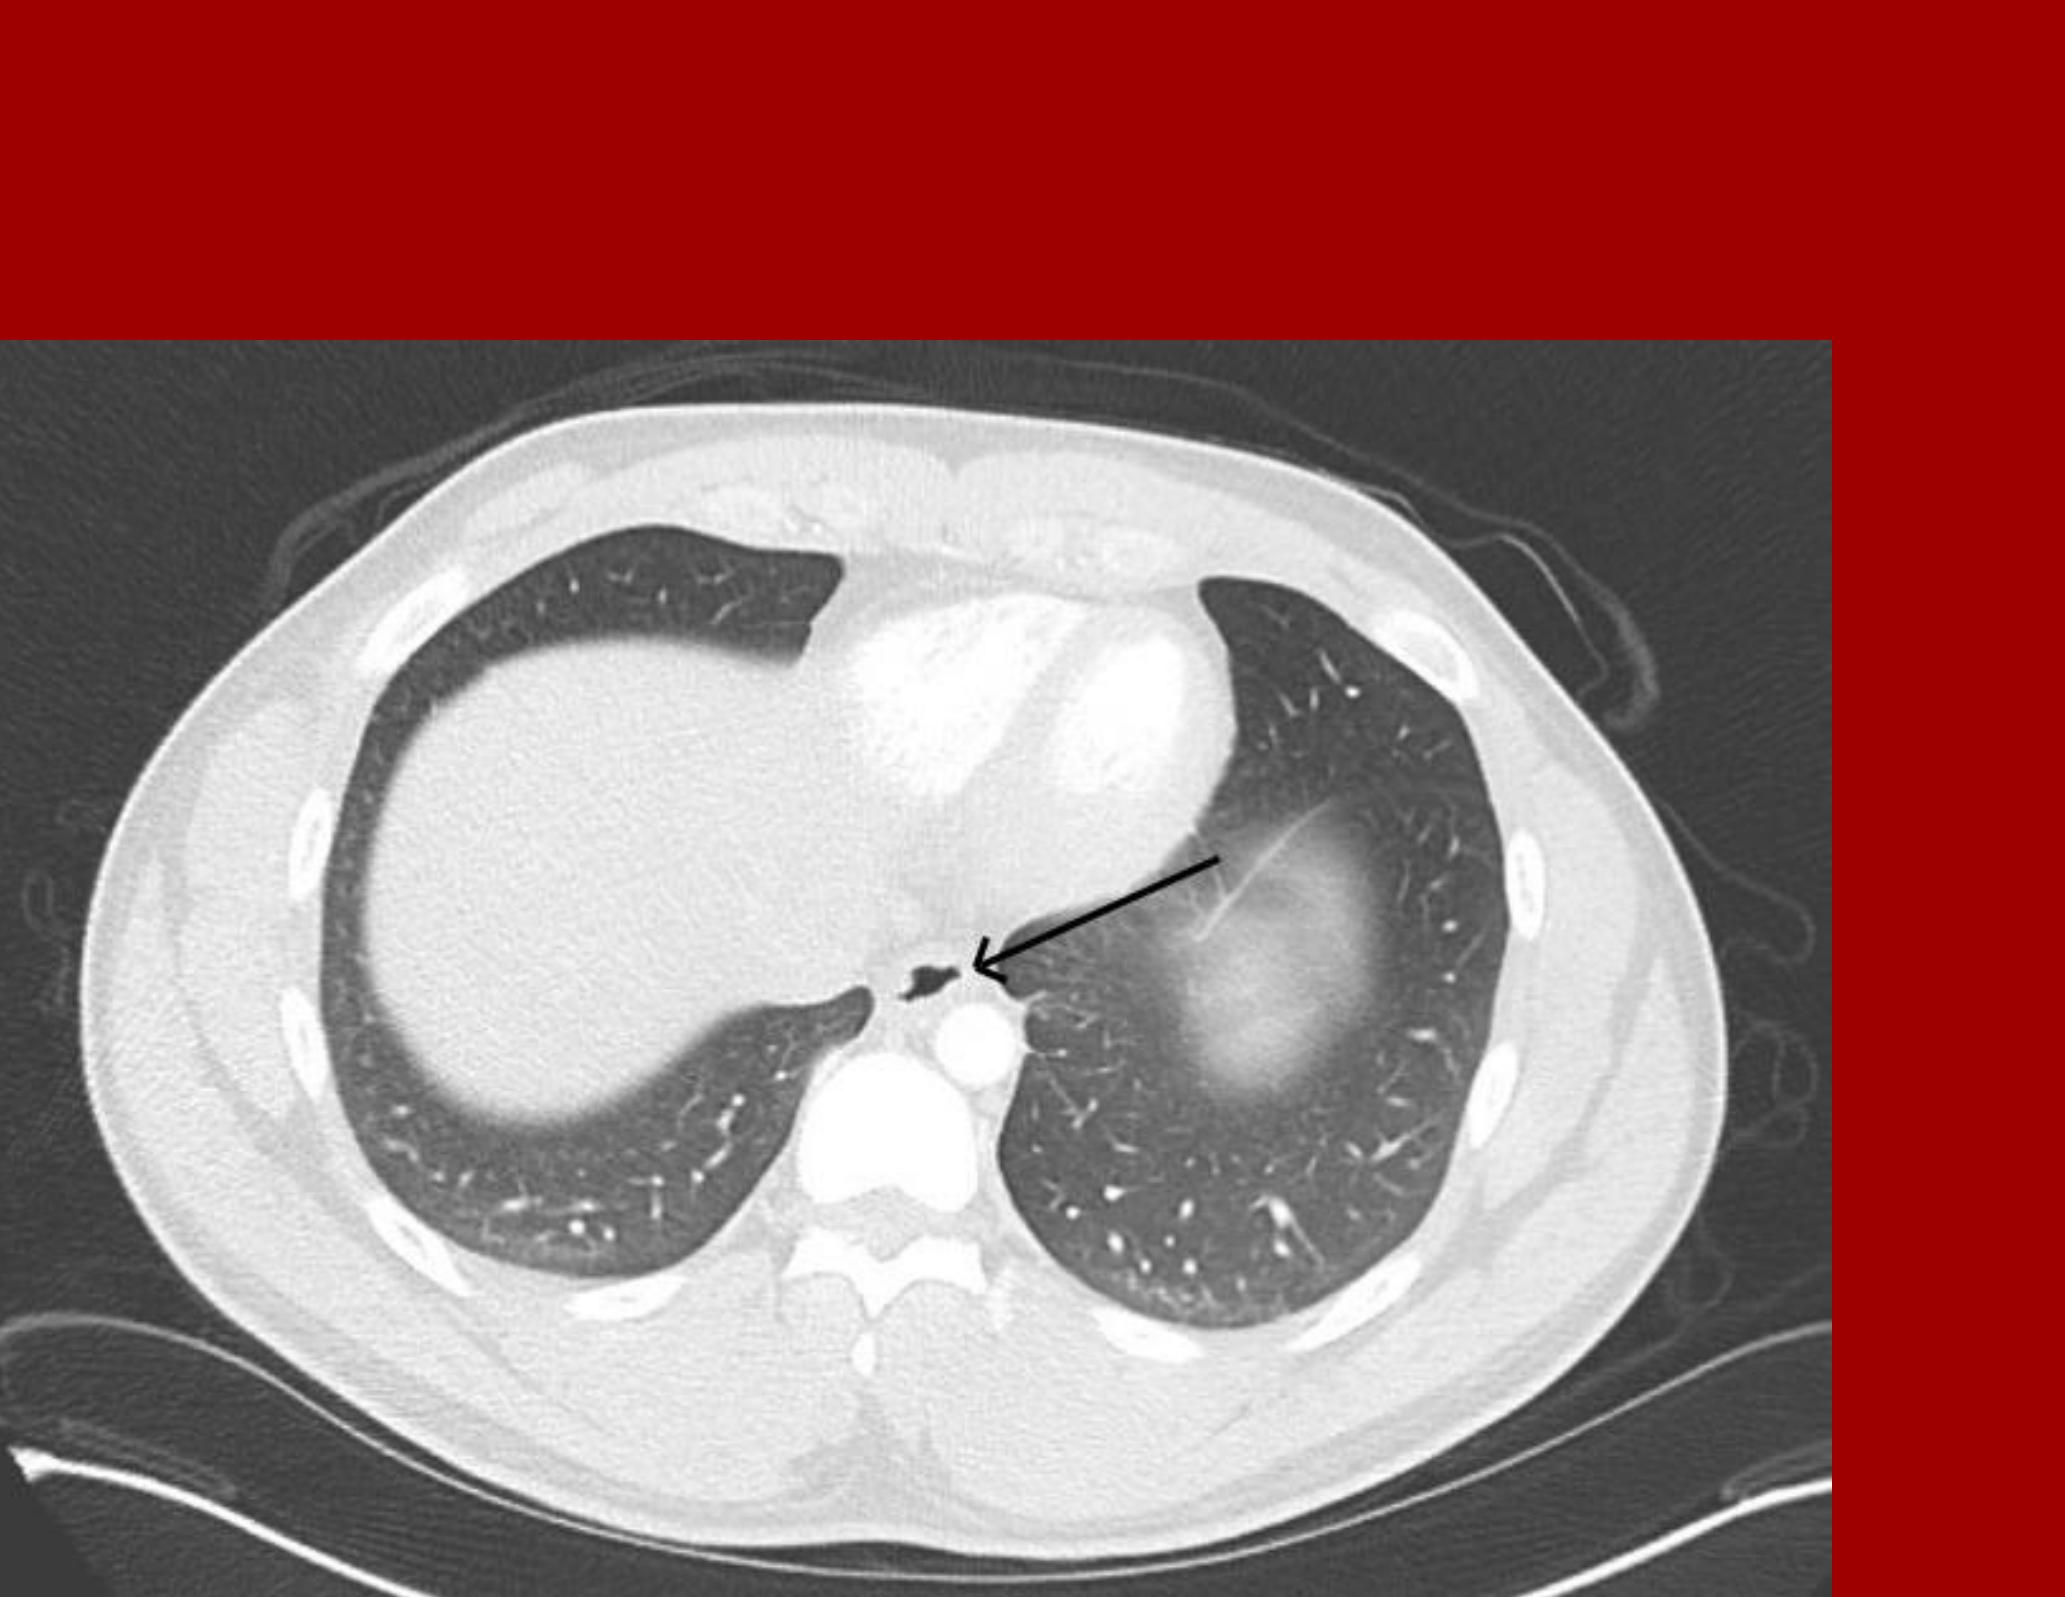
Axial view of CT angiogram of chest showing distal esophageal thickening as indicated by arrow.
